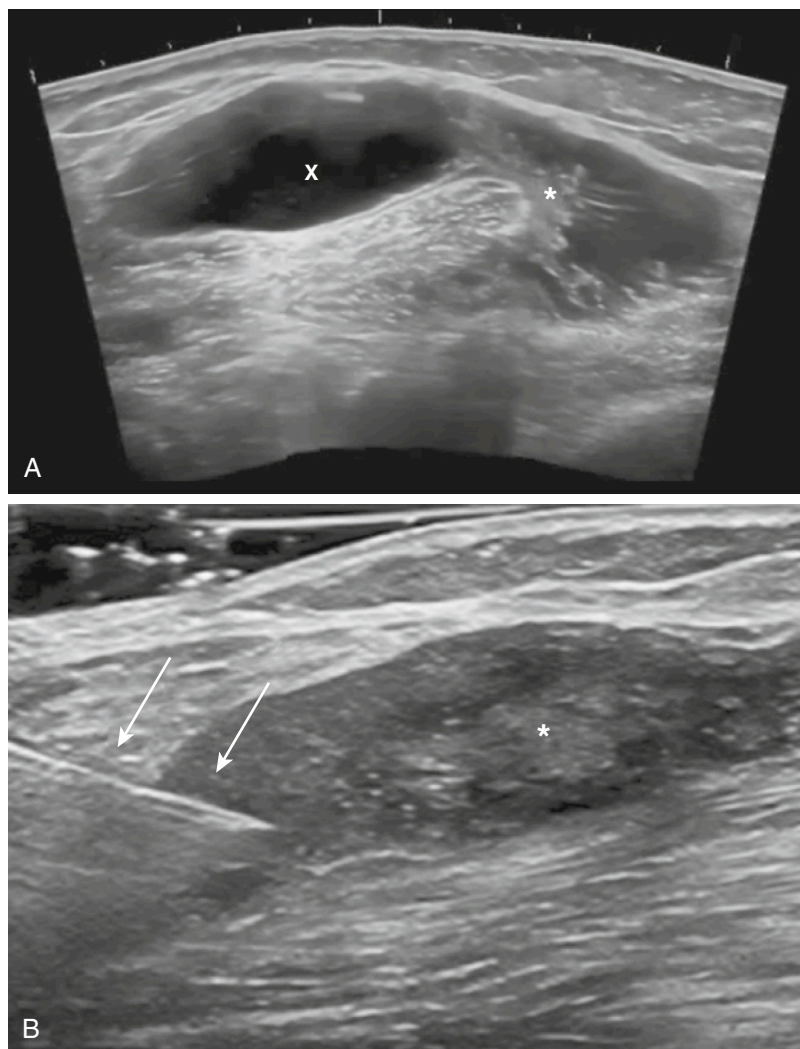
Ultrasound demonstrates large Baker's cysts in patients with knee osteoarthritis. A and B, The 12-MHz images depict Baker's cysts with various contents; local effusion (X) and synovial proliferation (*stars*) are shown. The image in A offers an extended-view reconstruction of the calf. In B the needle (*arrows*) used for guided local injection is seen.
